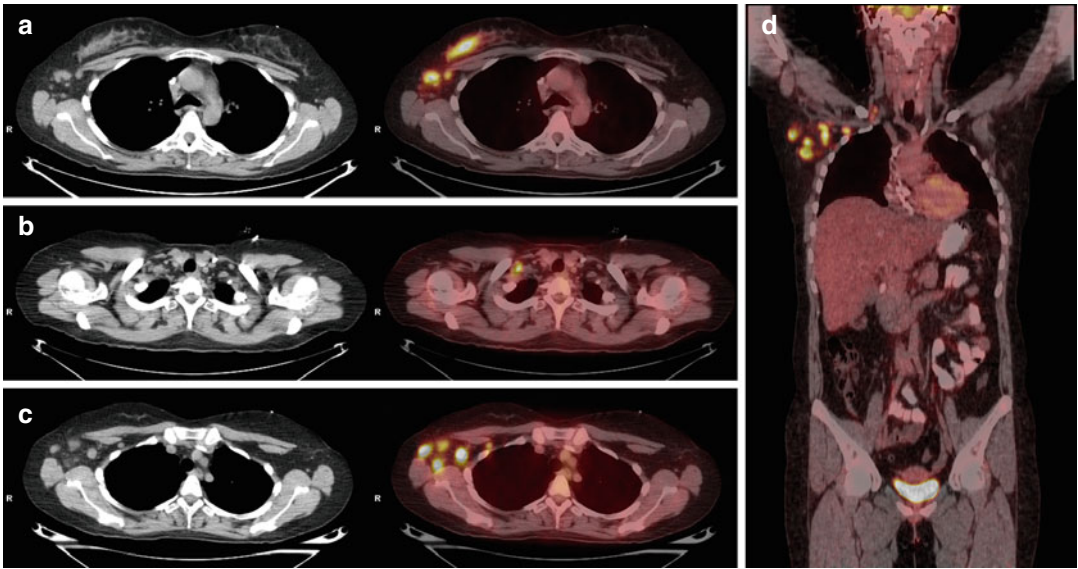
Transaxial CT and fused PET/CT images show an FDG-avid lesion (SUVmax: 13.7) in the upper outer quadrant of the right breast and ipsilateral hypermetabolic axillary subpectoral and supraclavicular
